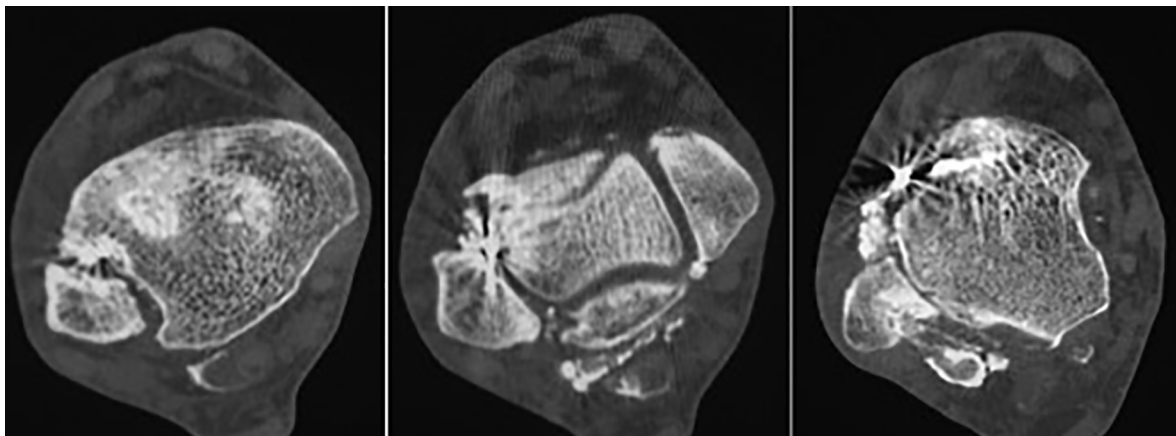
Axial computed tomography views of the ankle from proximally to distally at initial presentation.
